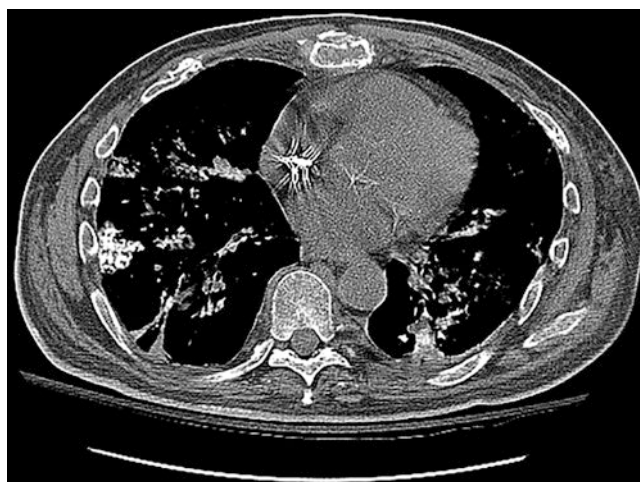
On a computed tomography scan of the chest, metastatic pulmonary calcification is seen as multiple consolidative calcific densities throughout both lungs
